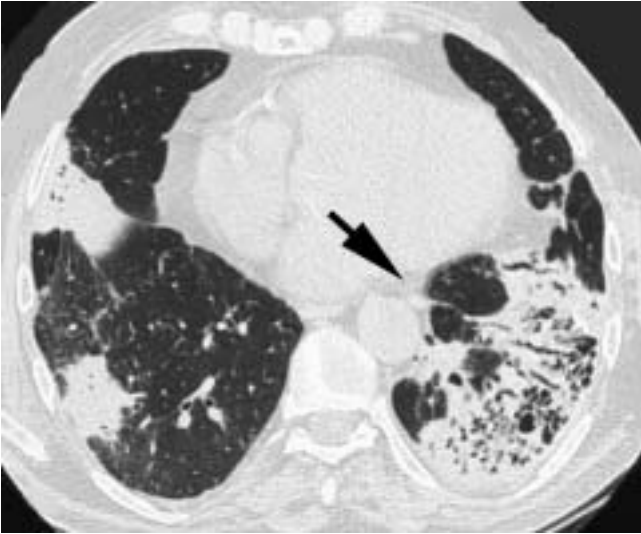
Computed tomography scan showing bilateral subpleural condensations in the left lower lobe with honeycombing, bronchiectasis and bronchiolectasis.
